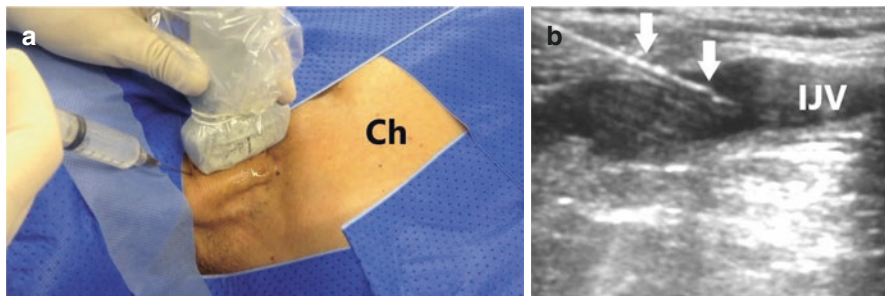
Longitudinal puncture of the internal jugular vein. (a) Ch-patient's chest. (b) Corresponding ultrasound image. IJV—internal jugular vein; white arrows—puncture needle
